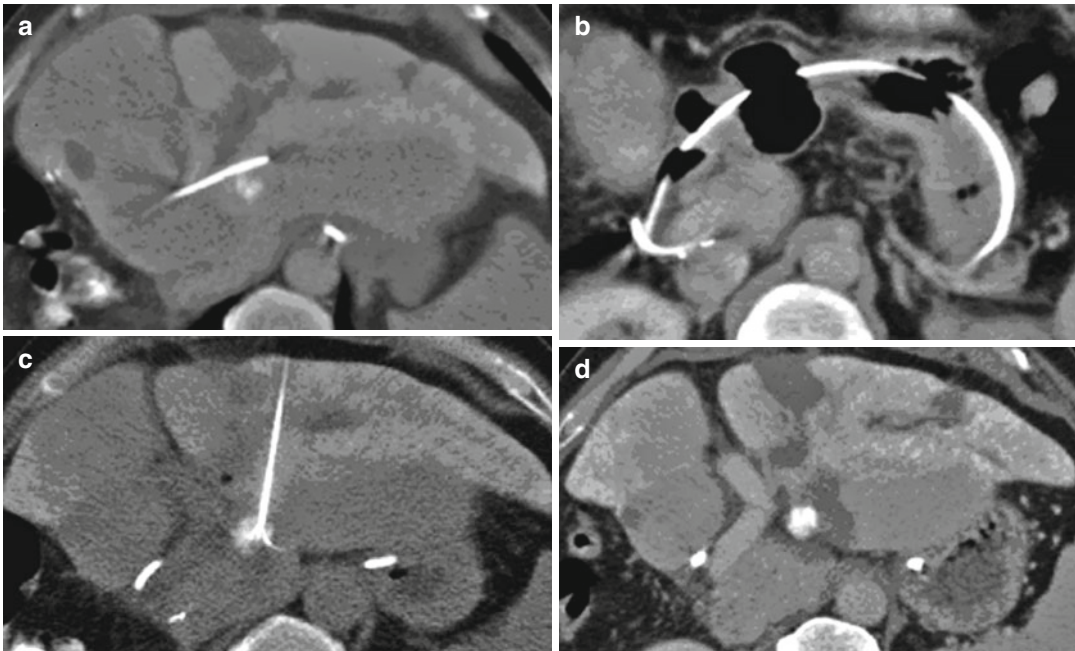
CT shows a recurrent HCC nodule in liver segment 3 after transarterial chemoembolization (a; *arrow*). Note the nasobiliary tube adjacent to the tumor. CT scan demonstrating the endoscopically placed nasobiliary tube that was used for continuous cooling of the adjacent bile
